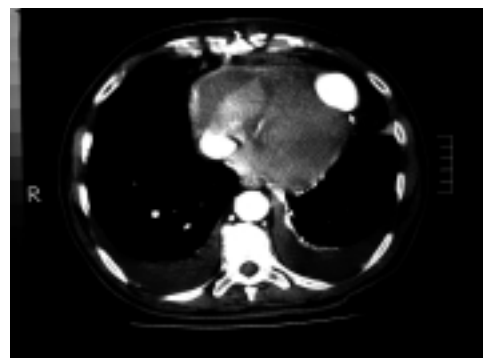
Computed tomographic scan showing delayed opacification of the pseudoaneurysm (white arrow).
